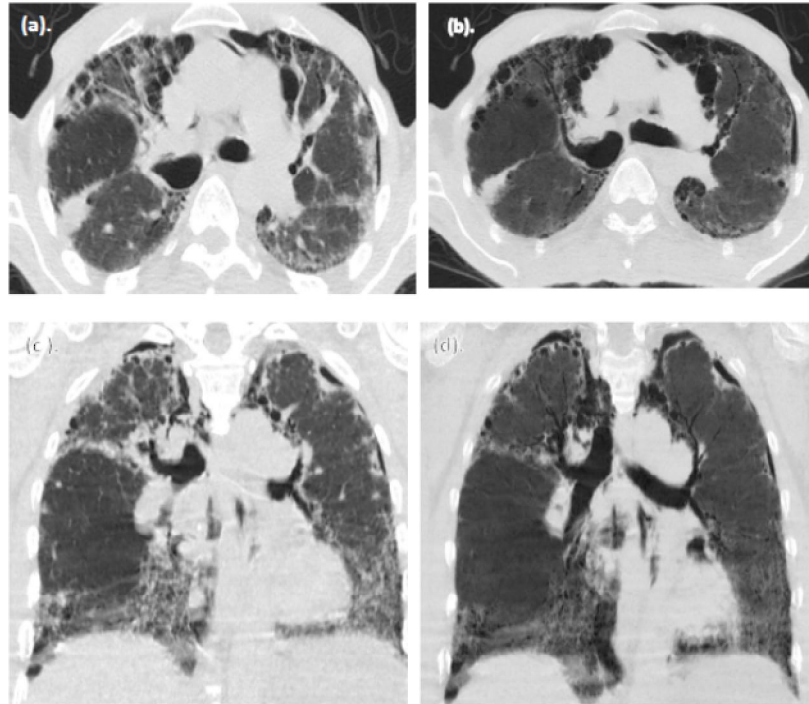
A 60 year old male patient (known ILD) presented with dyspnea and productive cough, no fever, no history of trauma, no related operations and no comorbidities. Axial Section and coronal reconstruction of non-contrast CT chest scan (a, c). Volumetric HRCT shows extensive fibrosis, bilateral apical minimal pneumothorax, cardiomegaly and dilated pulmonary artery; note that bronchiectasis is more evident at (b, d) MinIP projection in addition to other low attenuation patterns.
